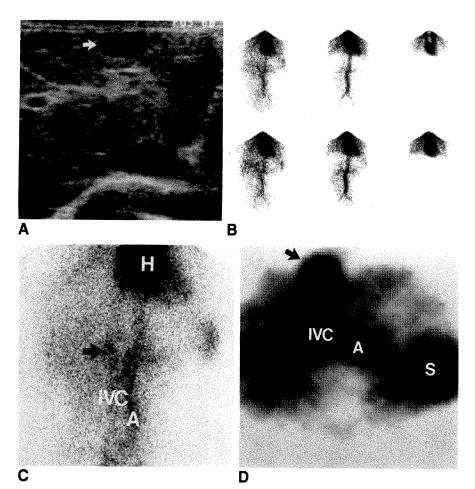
Atypical sonographic appearance of hemangioma in patient with history of colon cancer and chronic hepatitis.
